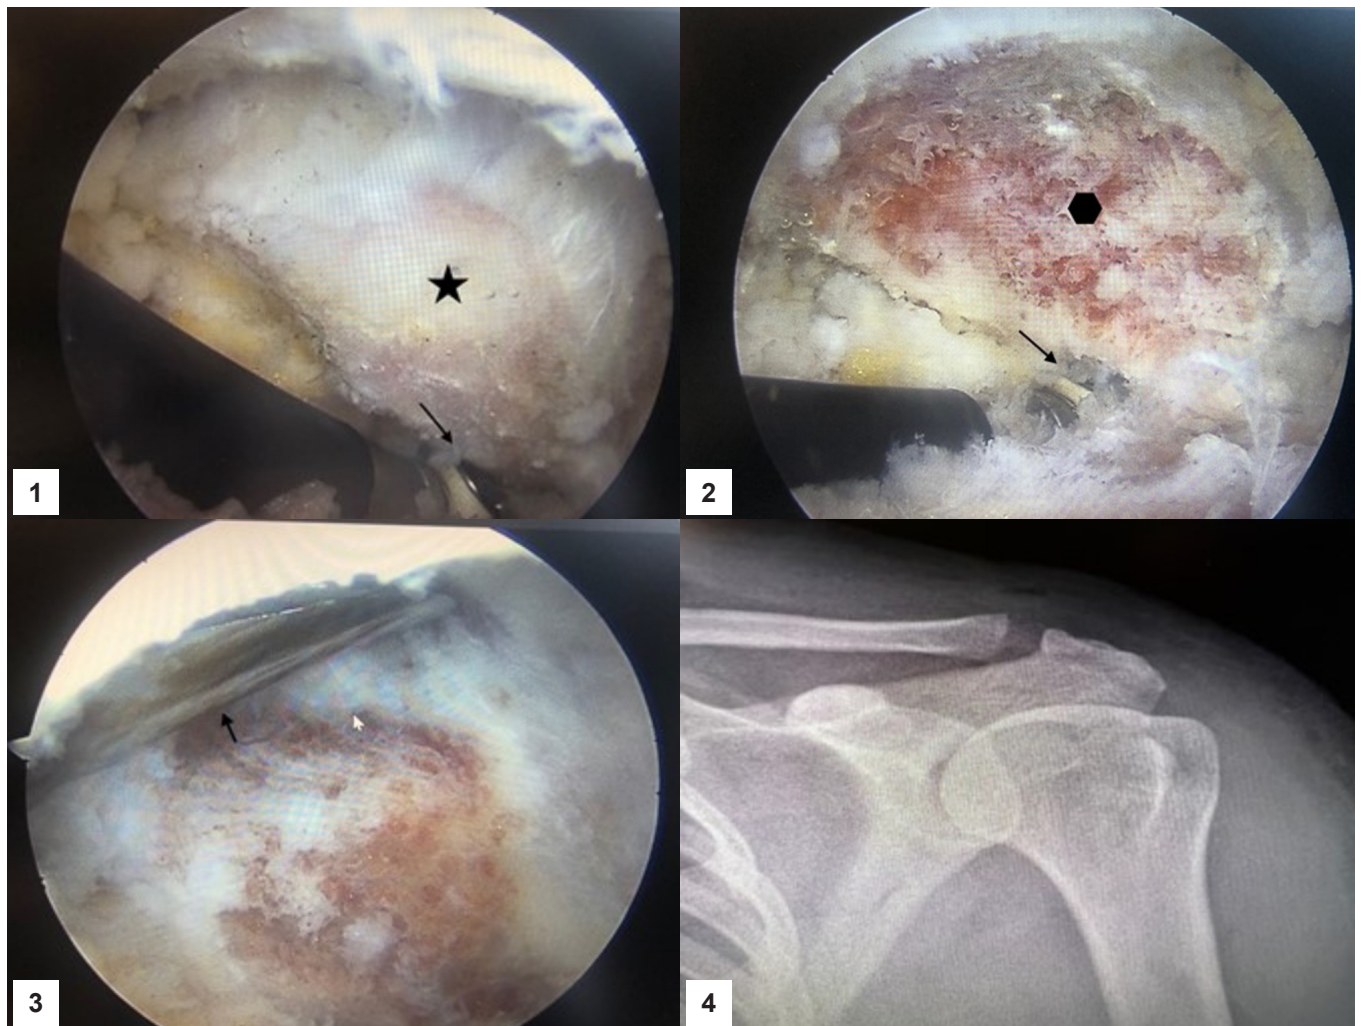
OA in the AC joint and impingement at the clavicle's distal end (asterisk). Cutting the inferior capsule using electrocautery (arrow). (2) DCE (polygon) from the anterior portal using a shaver; excision of inferior soft tissues using electrocautery (arrow). (3) DCE to fit a shaver that is 5 mm in diameter (black arrow). Protection of the posterior-upper ligament and capsular region to maintain AC joint stability (white arrow). (4) Standard shoulder anteroposterior radiograph to see the extent of DCE.
